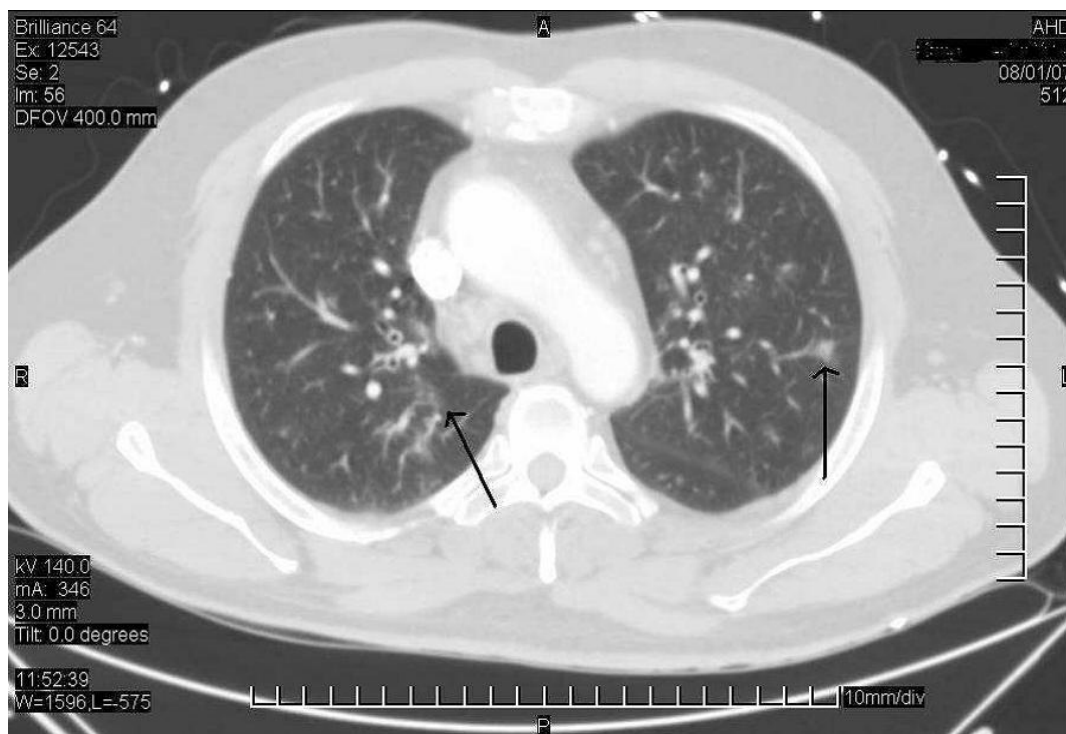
Chest CT scan showing patchy infiltrate (arrows) in the RUL, LUL.
